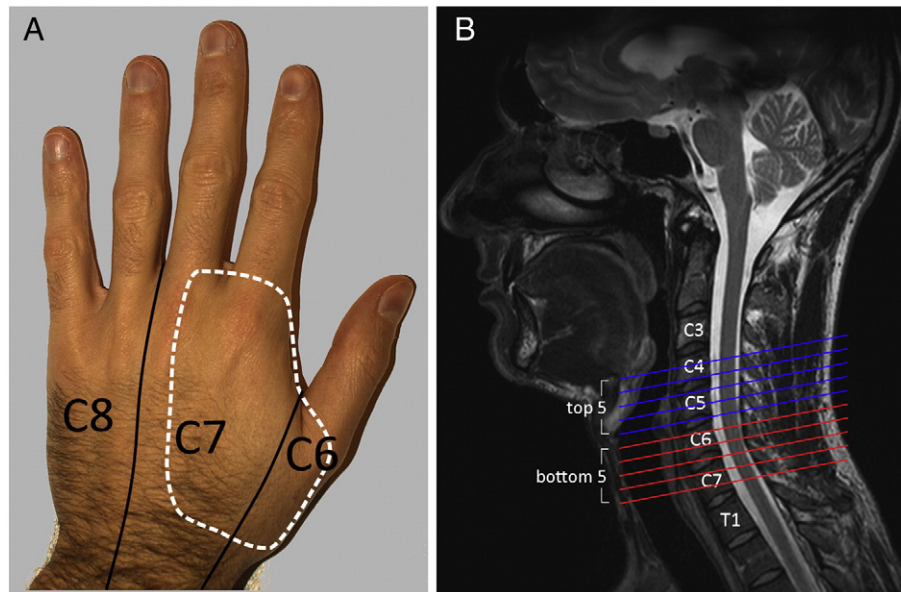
Stimulation site and MRI slice prescription. Both noxious and innocuous somatosensory stimuli were applied to the dorsum of the left hand (left panel, A), in the region corresponding to the C6 and C7 dermatomes. Functional MRI analysis was conducted on data from 10 consecutive, 4-mm-thick axial slices (in-plane resolution of 0.98×0.98 mm), oriented perpendicularly to the longitudinal axis of the spinal cord (right panel, B).
